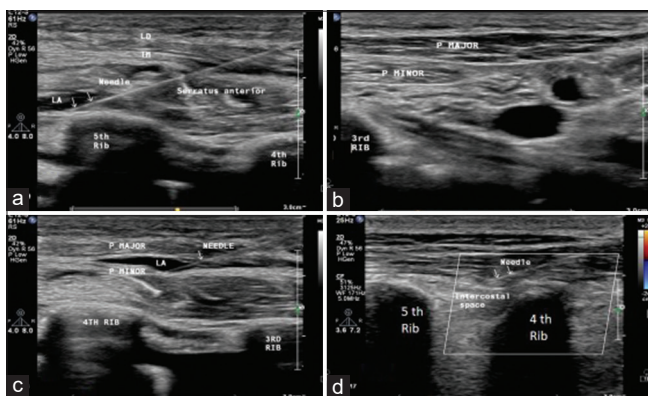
Depiction of the SAPB sonoanatomy with the needle directed (at the level of the fifth rib) toward the optimal plane for local anaesthetic deposition below the serratus anterior muscle (a); Ultra-sonographic image outlining the Pectoralis major and minor muscles (b); Pecs II block with the needle drug injection hydro-dissecting the plane between the pectoral muscles (c); Sonoanatomy of the intercostal musculature and adjacent ribs for administering ICNB (d). LA: Local anaesthetic; LD: Latissimus dorsi; TM: Teres Major; P Major: Pectoralis major; P Minor: Pectoralis minor
